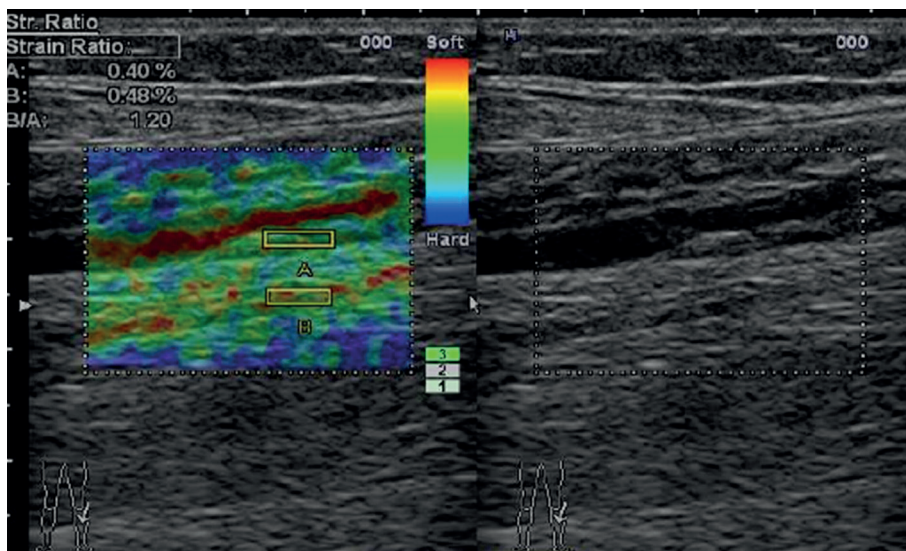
Ultrasound elastography image of sub-acute thrombosis.
